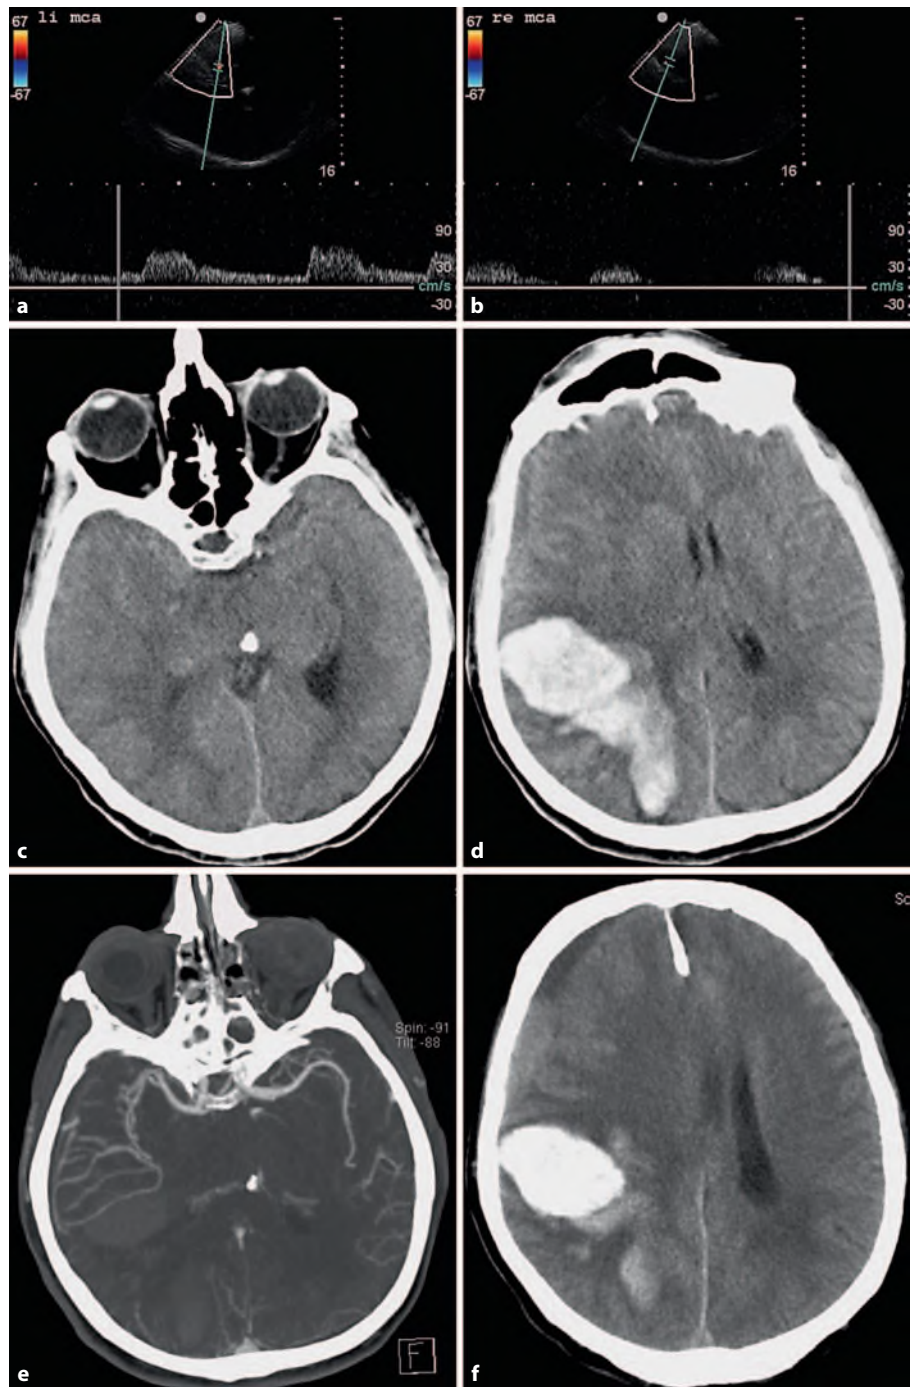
Images obtained in an 80-year-old patient with acute left-sided hemiparesis and neglect. a, b Unenhanced TCCS images obtained 30 min after symptom onset showing a patent left MCA and significant flow reduction in the right MCA, which was interpreted to be consistent with distal MCA occlusion (according to Zanette), but without a high-resistance flow pattern. c, d Unenhanced cerebral CT scans obtained 60 min later, showing a midline shift at the level of the circle of Willis (c) and a large right-sided parietooccipital atypical ICH with a small-convexity subdural hematoma (d). e, f After intubation and before neurosurgical evacuation, CTA revealed severe dislocation of the right MCA, leading to a near-perpendicular angle of insonation for TCCS; this was also reflected in the absent high-resistance flow pattern, which would be expected in cases of distal MCA occlusions.
